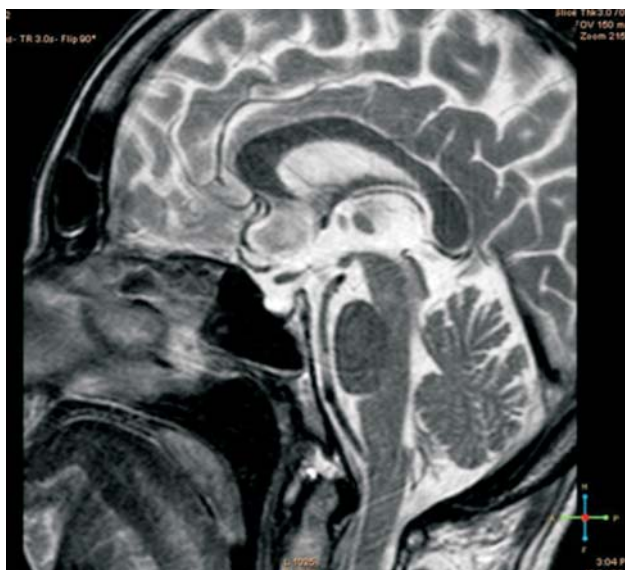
T1W MRI of brain showing empty sella turcica.
